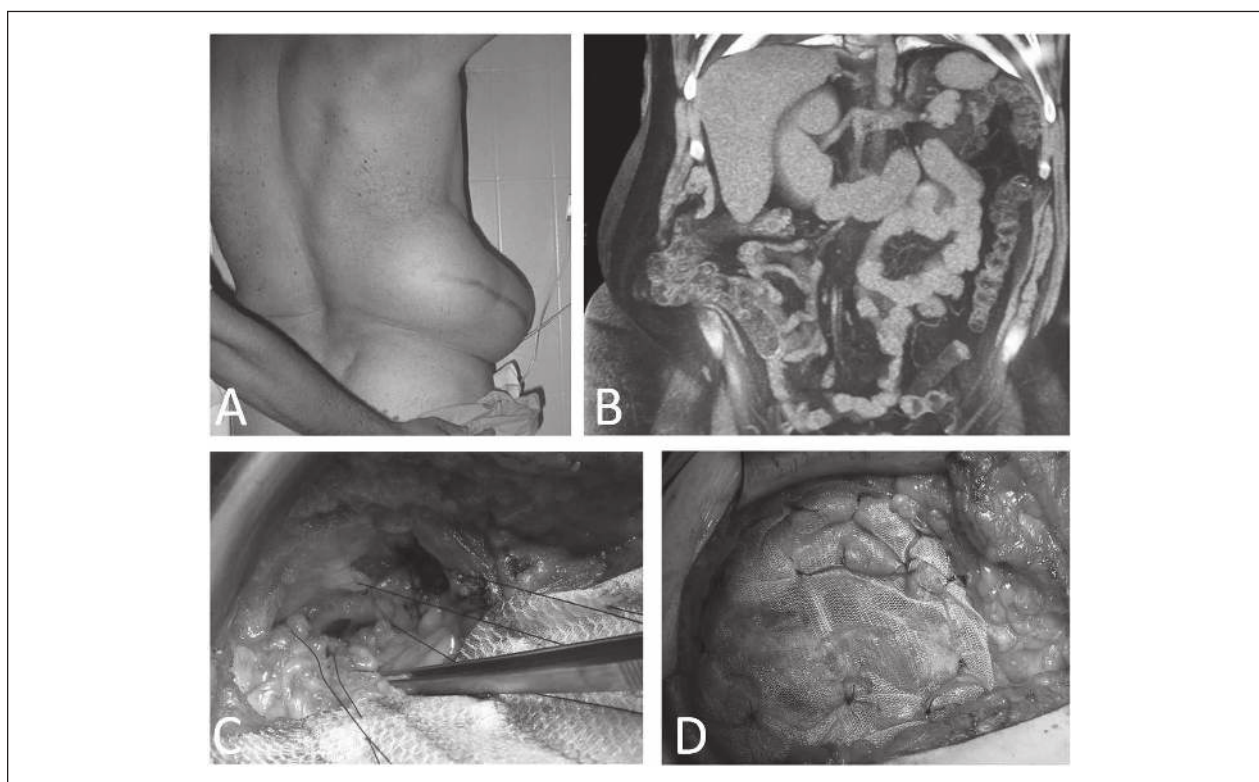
Lumbar hernia—open surgery (A) physical exam, (B) computed tomography study, (C) extraperitoneal mesh repair, and (D) only mesh repair
